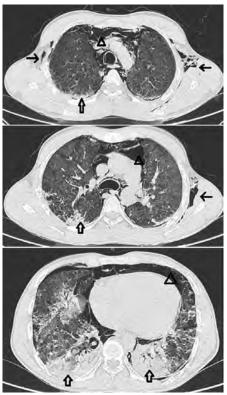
High-resolution computed tomography (HRCT) chest was performed 8 days postingestion of paraguat which revealed diffuse inter and intralobular septal thickening with superimposed GGOs in bilateral lung fields. Multiple patches of consolidation, predominantly in the dependent portion in bilateral upper, lower lobes, and right middle lobes were noted. Minimal bilateral pneumothorax with extensive pneumomediastinum and subcutaneous emphysema were also seen
